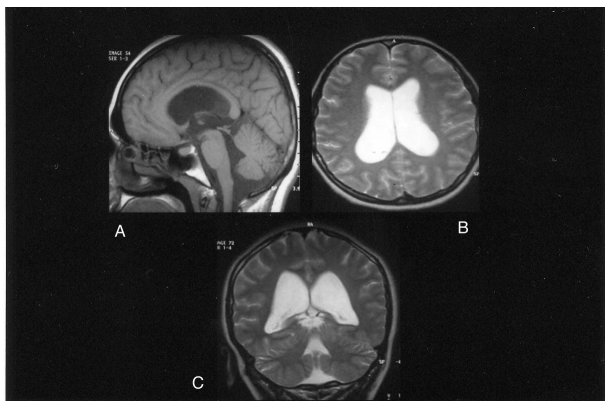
Follow-up MR examination six months after onset of symptoms - sagittal T1-weighted without contrast enhancement (Fig. 4A), axial T2-weighted (Fig. 4B) and coronal T2-weighted (Fig. 4C) MR images demonstrate communicating hydrocephalus is stable with no progression of findings.
